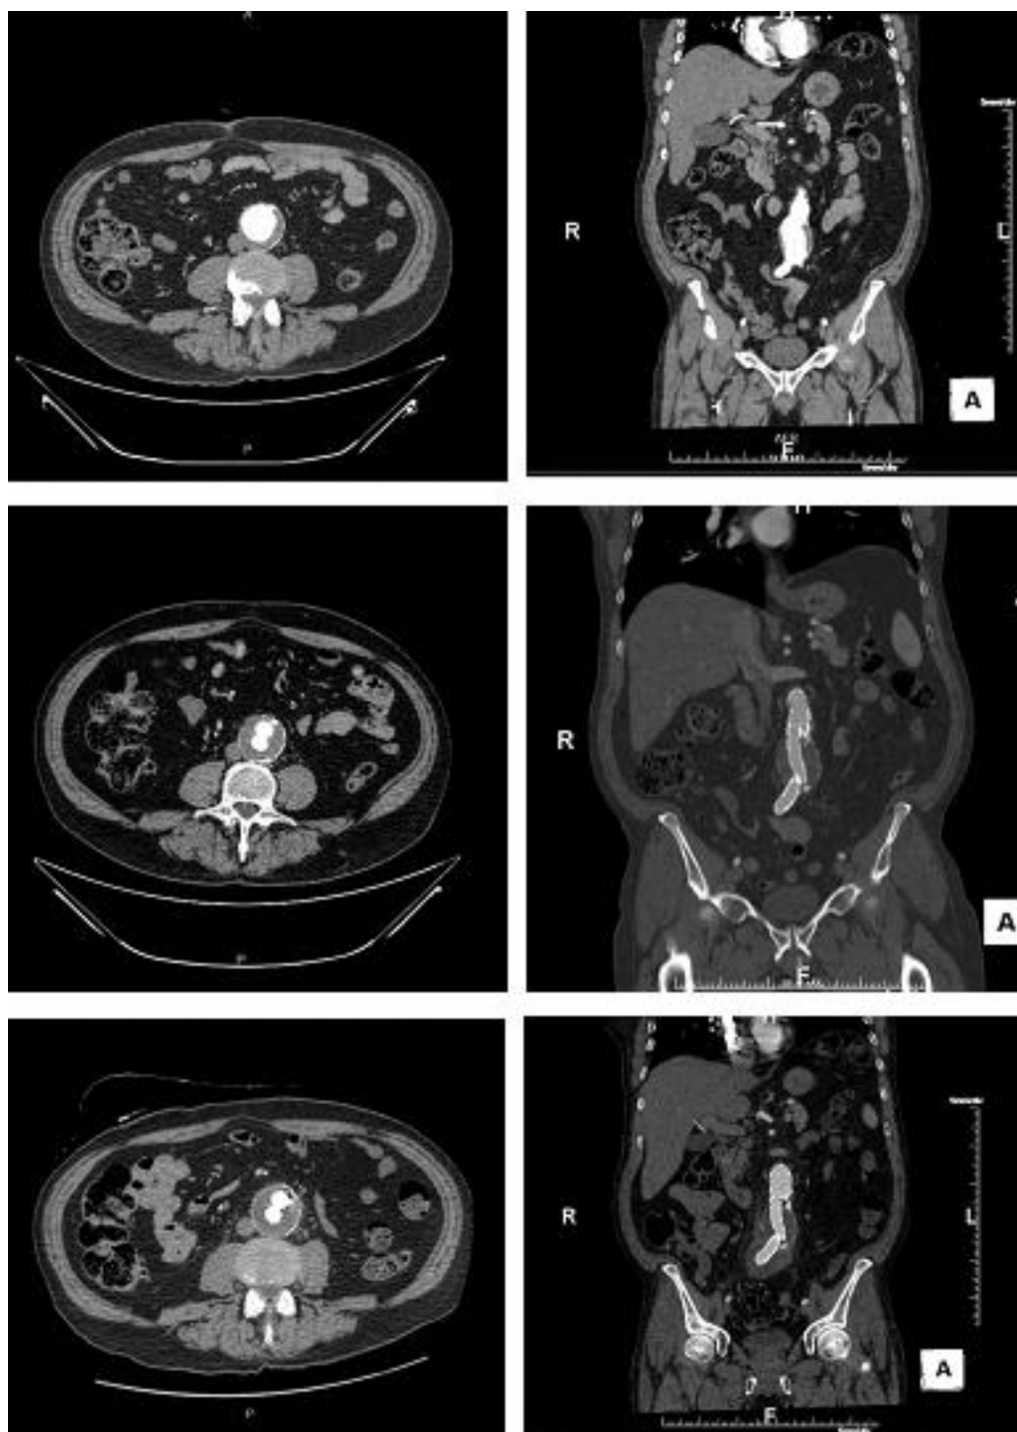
Axial and coronal computed tomography (CT) images demonstrating progression of aneurysm: *top*, before endovascular repair; *middle*, after endovascular repair; *bottom*, before in situ reconstruction.
